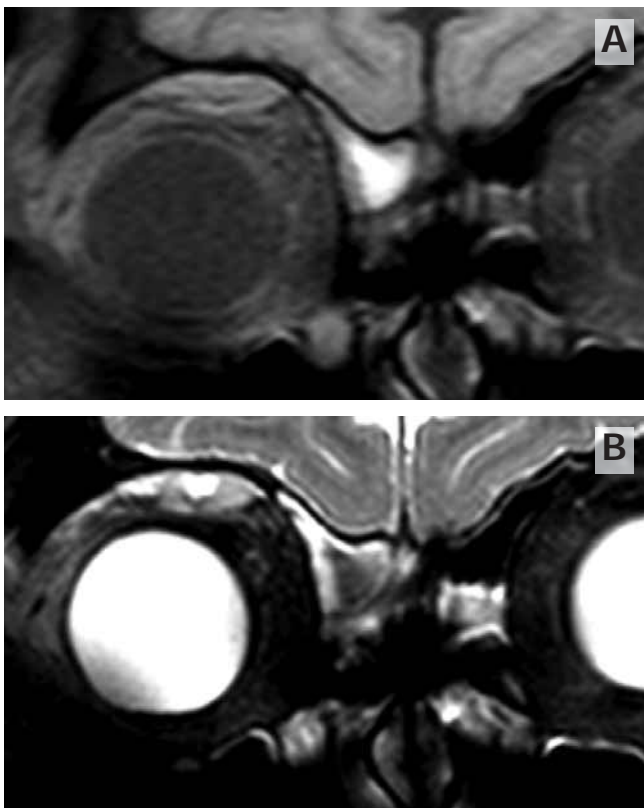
Case 1. (A) Magnetic resonance imaging. T1-weighted image showing a high-to-intermediate signal intensity lesion in the right supraorbital area. (B) T2-weighted image showing a high signal intensity. Right frontal sinusitis is also apparent.
